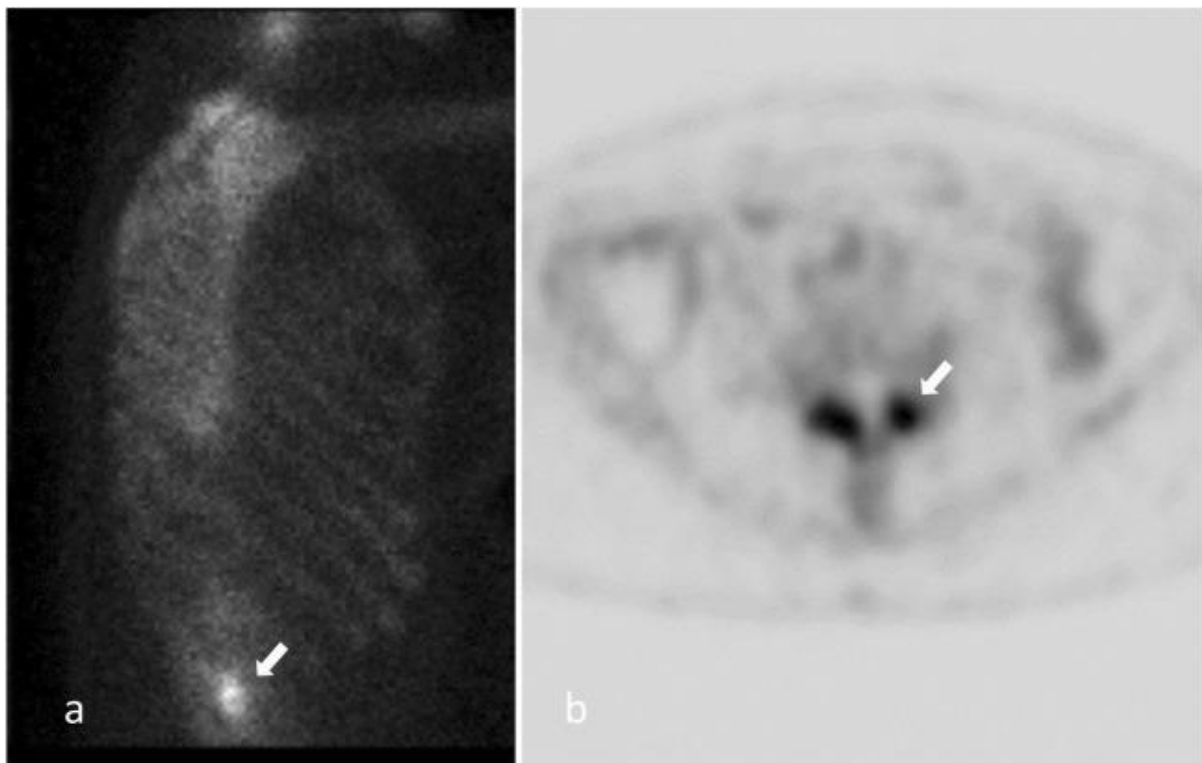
SPECT imaging of FJ. The user is hyper-focused on bone scintigraphy, specifically on the inflammation of the FJ capsule, shown by the white arrow.<sup>21</sup>
